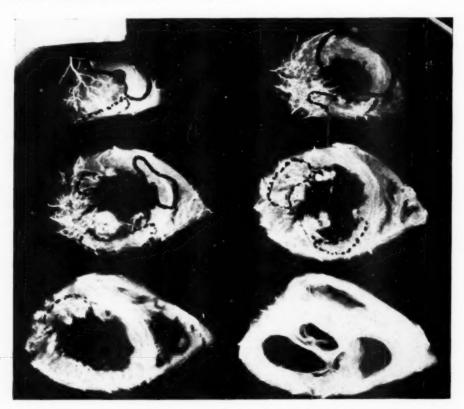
Roentgenogram of the injected heart in Case 73, showing old healed infarcts in broken outline and recent infarct of the anterior wall and septum in solid outline.
